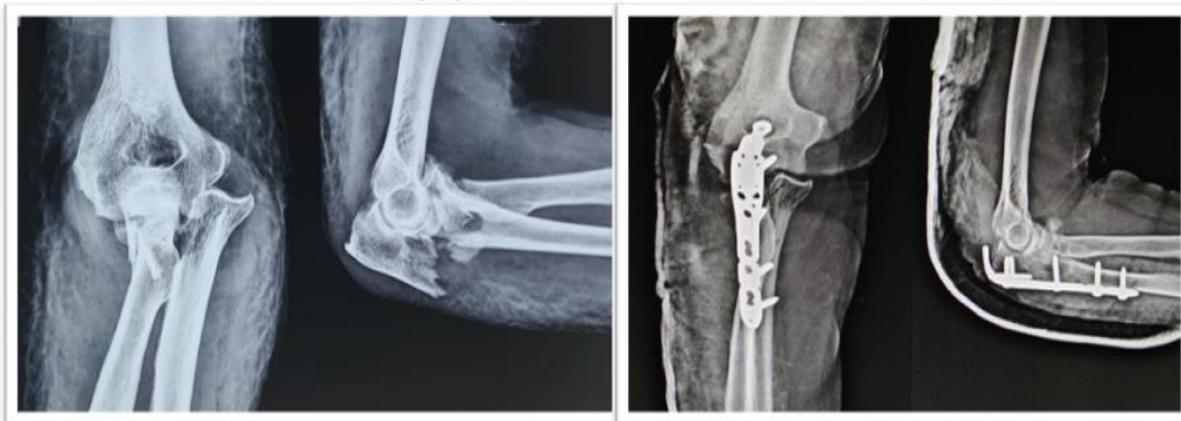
Preoperative anteroposterior and lateral views showing a proximal ulnar fracture with associated radial head dislocation (Monteggia lesion) (Left). Postoperative radiographs demonstrating anatomical restoration of ulnar alignment with plate osteosynthesis (Right).
